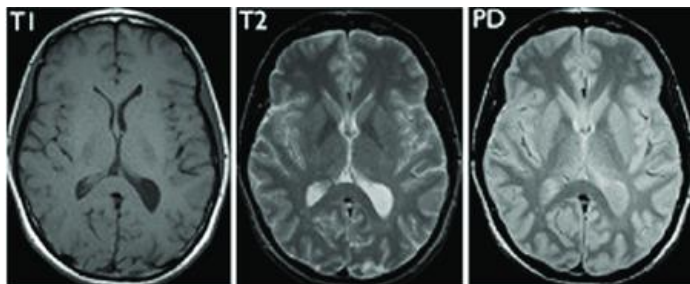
Sample of MRI images for a normal brain.
